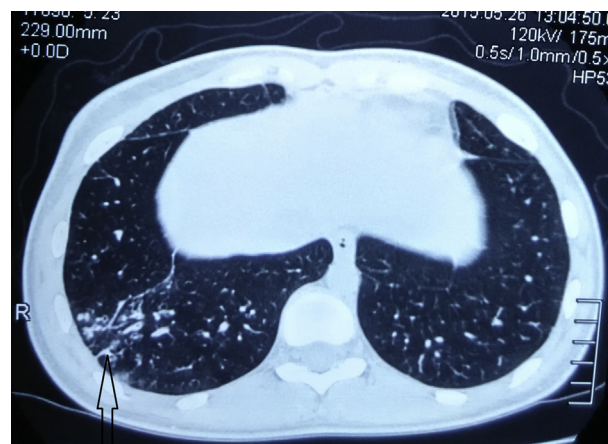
Axial section CT-thorax showing bronchiectasis.
